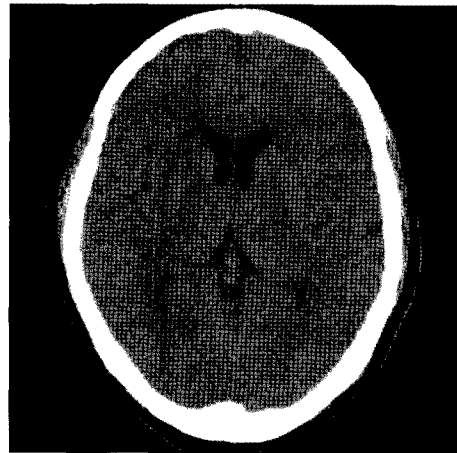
Follow up CT scan after 22 hours. Note that the gyriform enhancement has disappeared.
